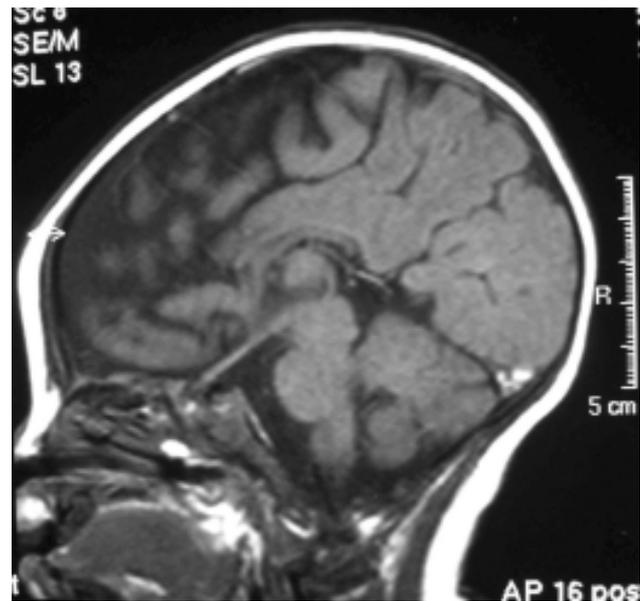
MRI brain showed marked thinning of the corpus callosum, particularly evident in the sagittal planes. This had involved the rostrum, body and splenium.
